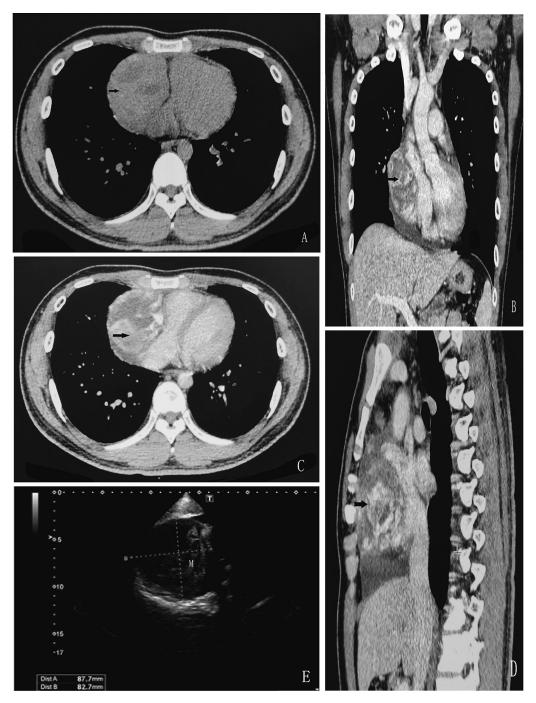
Palin CT imaging showed an irregular, large mass in the right pericardium A together with thickened pericardium, pericardial effusion; the mass was inhomogeneous enhancement and the right atrium was invaded after enhancement scan (B-D). Transthoracic echocardiographic suggested abnormal echo mass in pericardial cavity (E).
